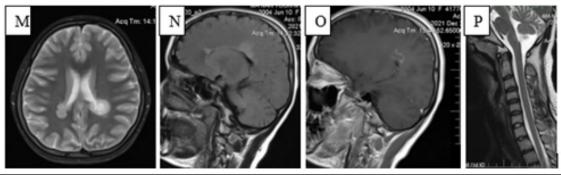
MRI (Brain and spine) showed multiple periventricular white matter lesions with active lesion and Dawson's finger appearance and normal spine MRI (Case 2).
